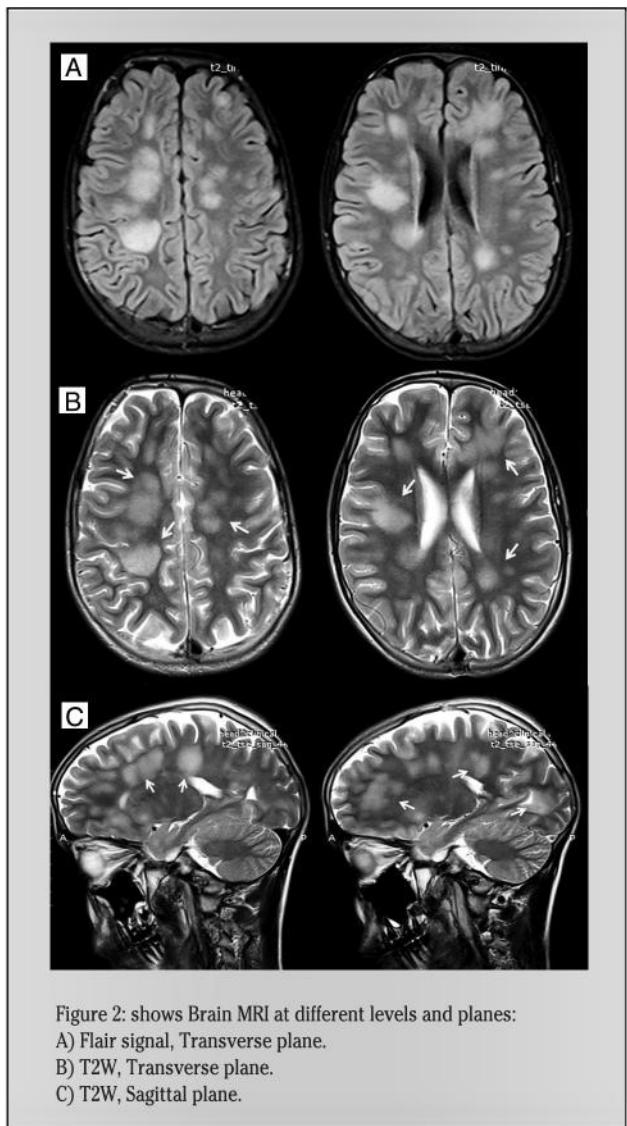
shows Brain MRI at different levels and planes:
